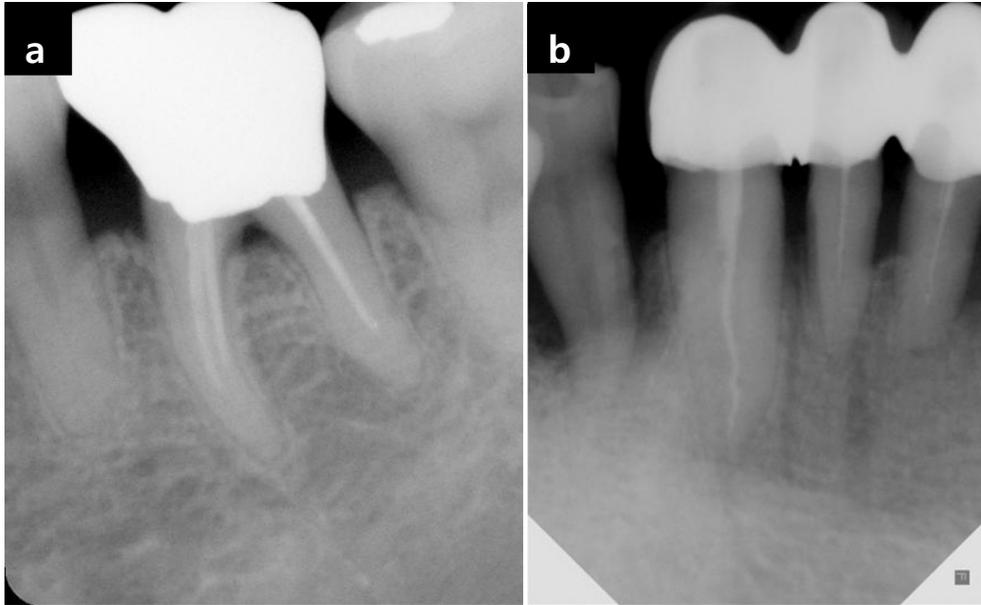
Radiographs of endodontically treated teeth assessed as poor endodontic filling (PE) (a) too short, (b) obvious voids are present.
